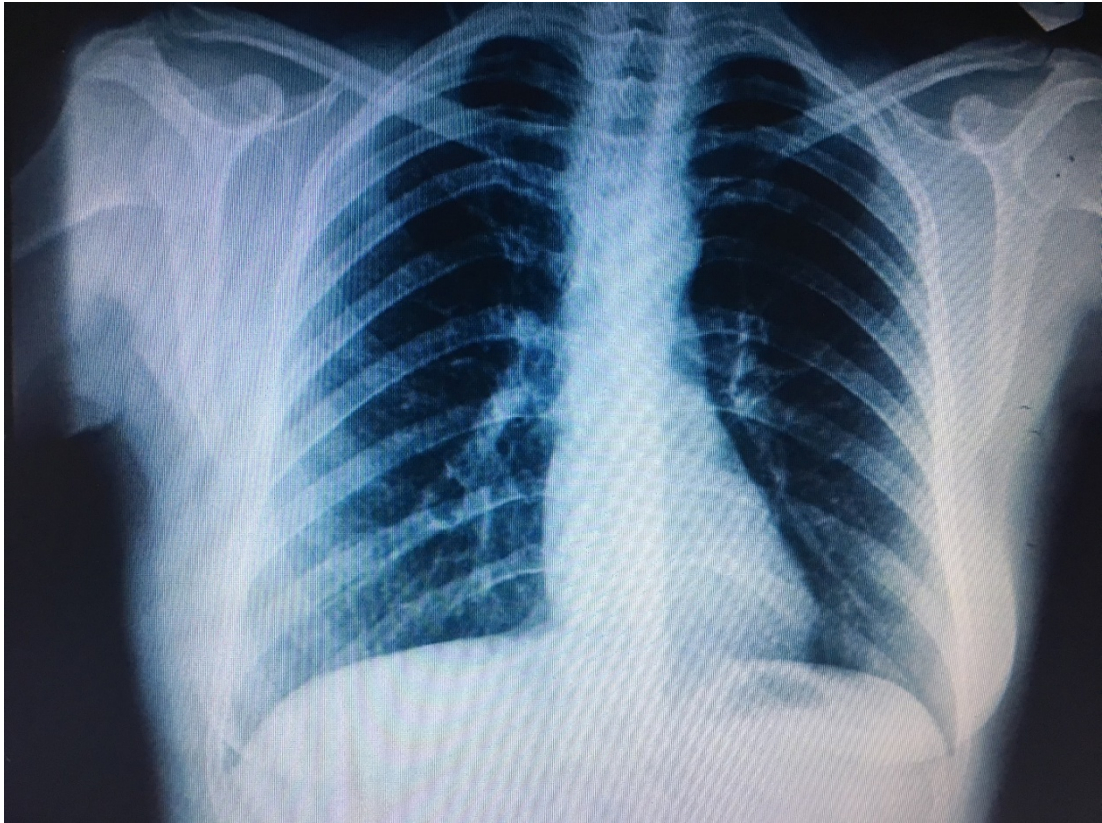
Initial normal chest x-ray
